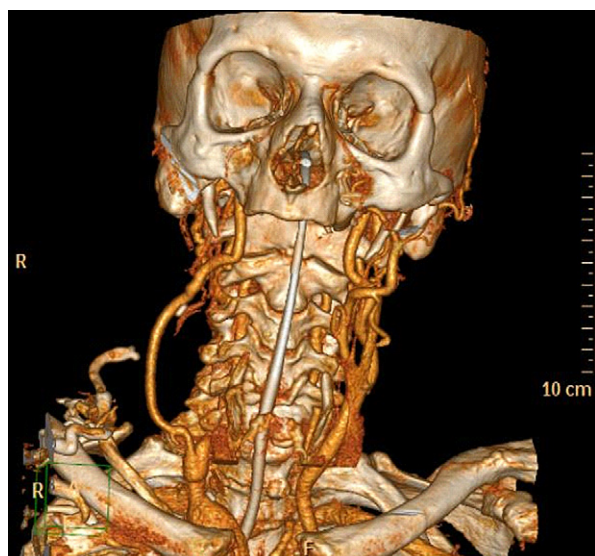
Post-operative CT angiogram confirming graft patency.
